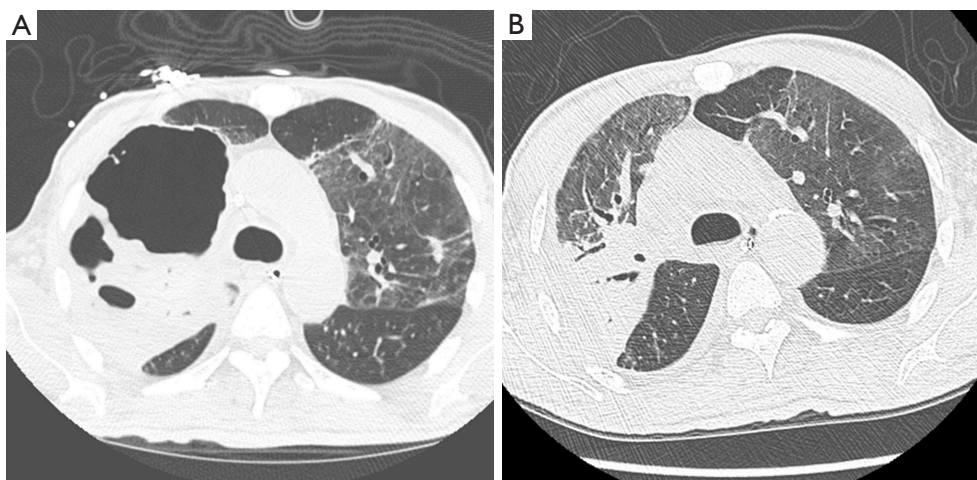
Impressive radiologic improvement over the course of critical care stay, in a 56-year-old female with prolonged mechanical ventilation. (A) Initial CT images revealing significant RUL pulmonary gangrene (max diameter 13.5 cm). (B) CT images obtained 4 weeks later showing marked radiologic evolution and a resolving cavity. The patient was ventilated and required tracheostomy. No surgery was performed. CT, computed tomography; RUL, right upper lobe.
